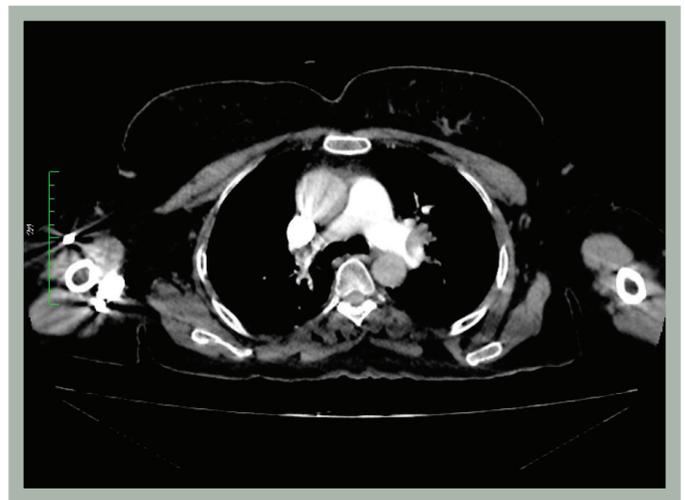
Contrast enhanced computed tomography scan demonstrating left main pulmonary artery thromboembolism
